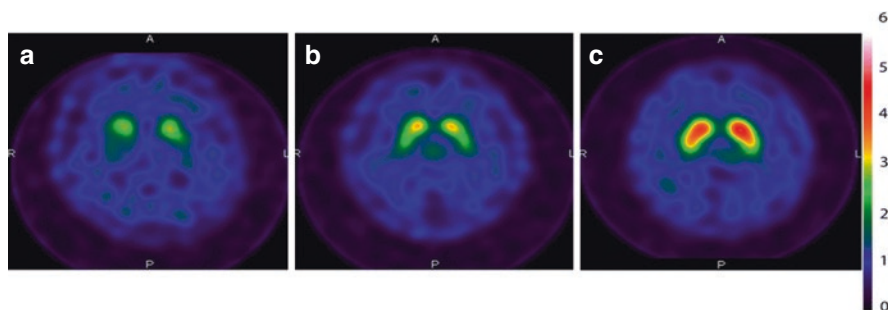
Representative ^{123}I -FP-CIT SPECT scan of: (a) a 72-year-old man with DLB; (b) a 72-year-old woman with prodromal DLB and (c) a 74-year-old woman with AD. In both DLB and prodromal DLB, there is a significantly decreased uptake of tracer compared to AD. However, the difference between the two DLB patients is not significant. (Reproduced from Kasanuki et al. 2017 with permission from Springer Nature)
